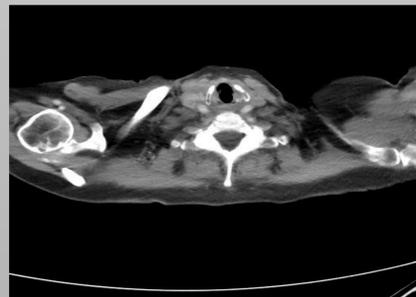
CT showing Right sided Cdep with clinical presentation of Calcific tendinitis
